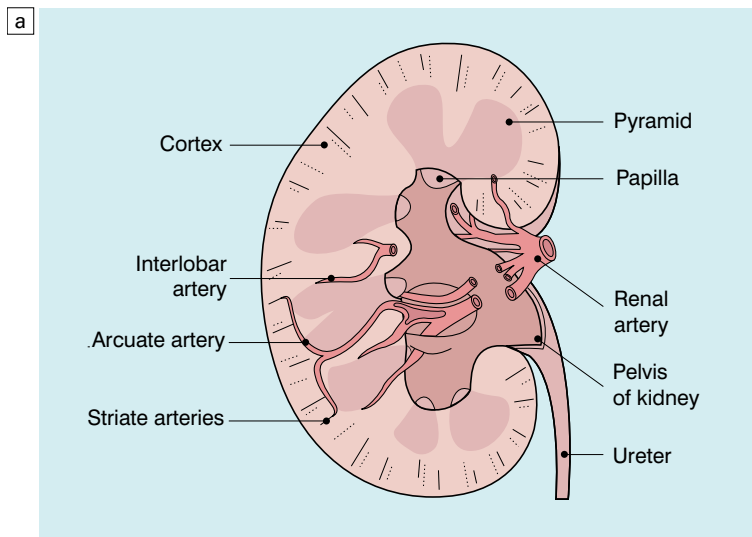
(a) (b) Colour flow Doppler demonstrating segmental, interlobar, arcuate and interlobular or striate vessels.
